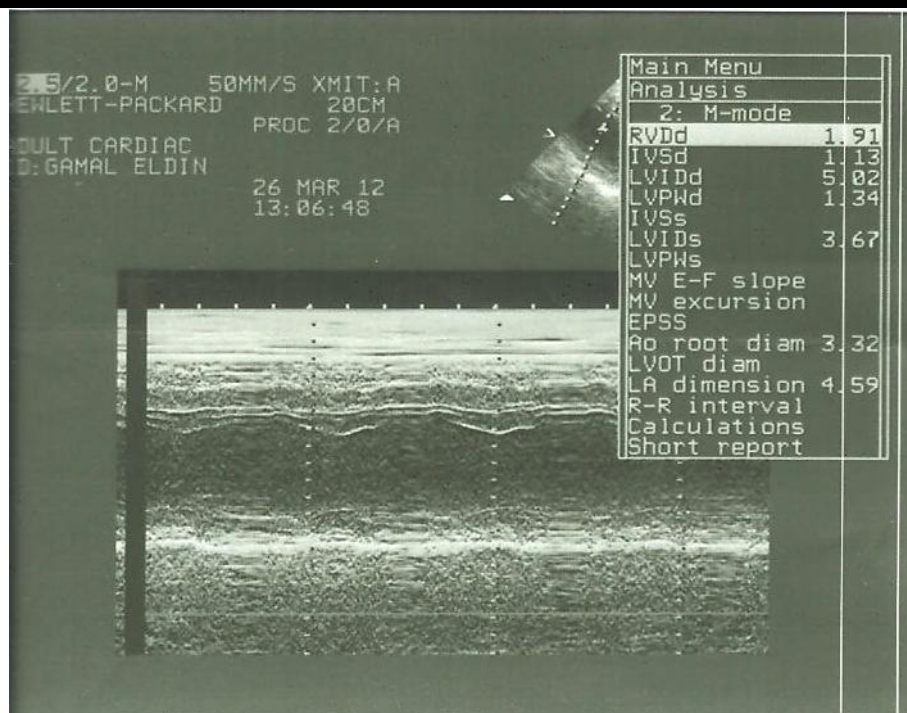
resting echocardiogram showing left ventricular dimensions.
